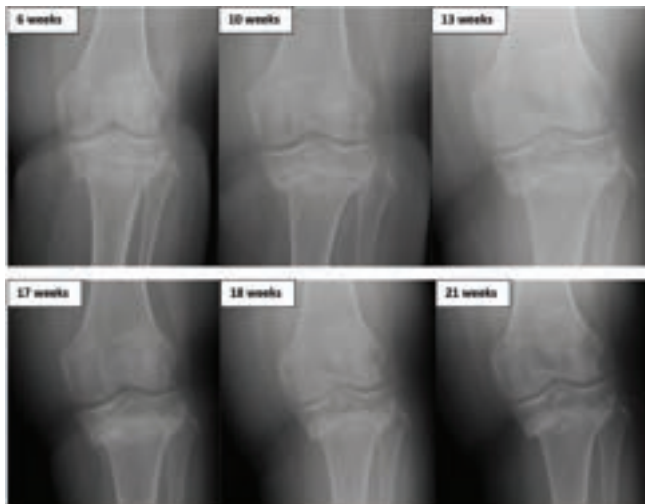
AP radiographs at 6 weeks, 10 weeks, 13 weeks, 17 weeks, 18 weeks, and 21 weeks post procedure demonstrating progressive varus collapse, and fracture healing.
